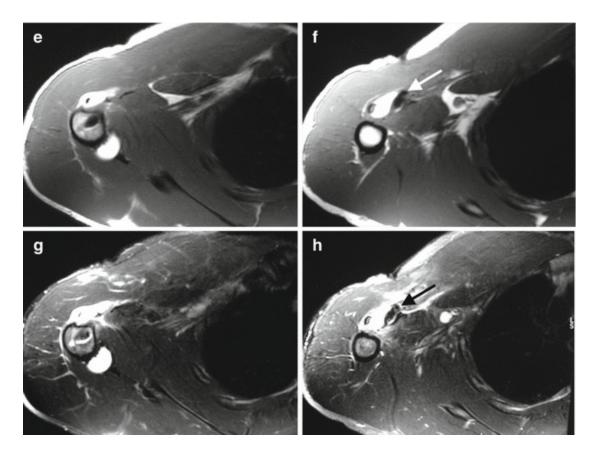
Re-rupture of pectoralis tendon major tendon 45 days after surgical repair with surgical anchors. Anteroposterior radiograph of the shoulder (a) shows dislocation of the inferior anchor (*arrow*). Transverse ultrasound images (b–d) show fluid collection and hyperechogenic foci at humeral insertion. Axial proton density-weighted MRI (e–h) show the inferior anchor (*arrow*) displaced proximally and a fluid collection interposed at the humeral insertion
